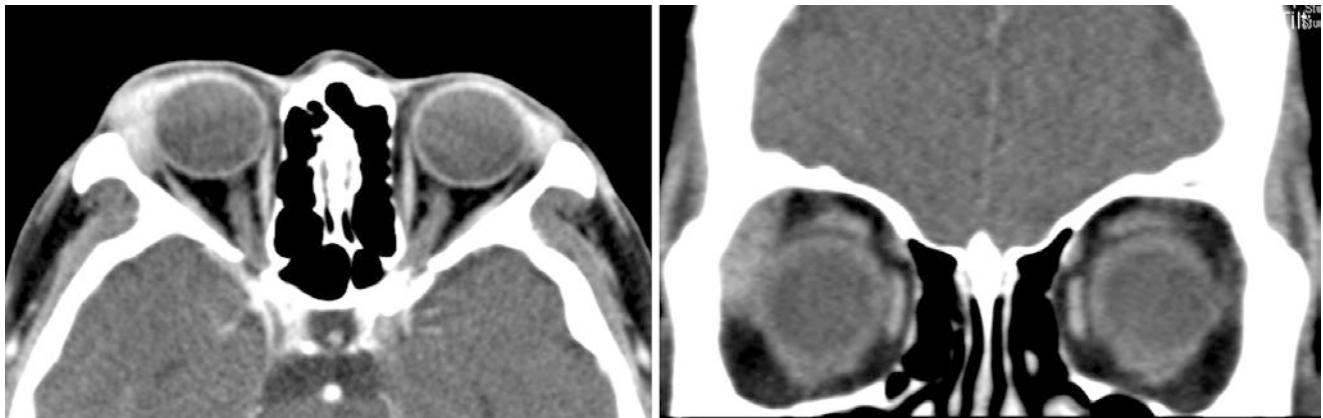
Axial and coronal post-contrast CT images showing diffuse, homogeneous enlargement of the right lacrimal gland
